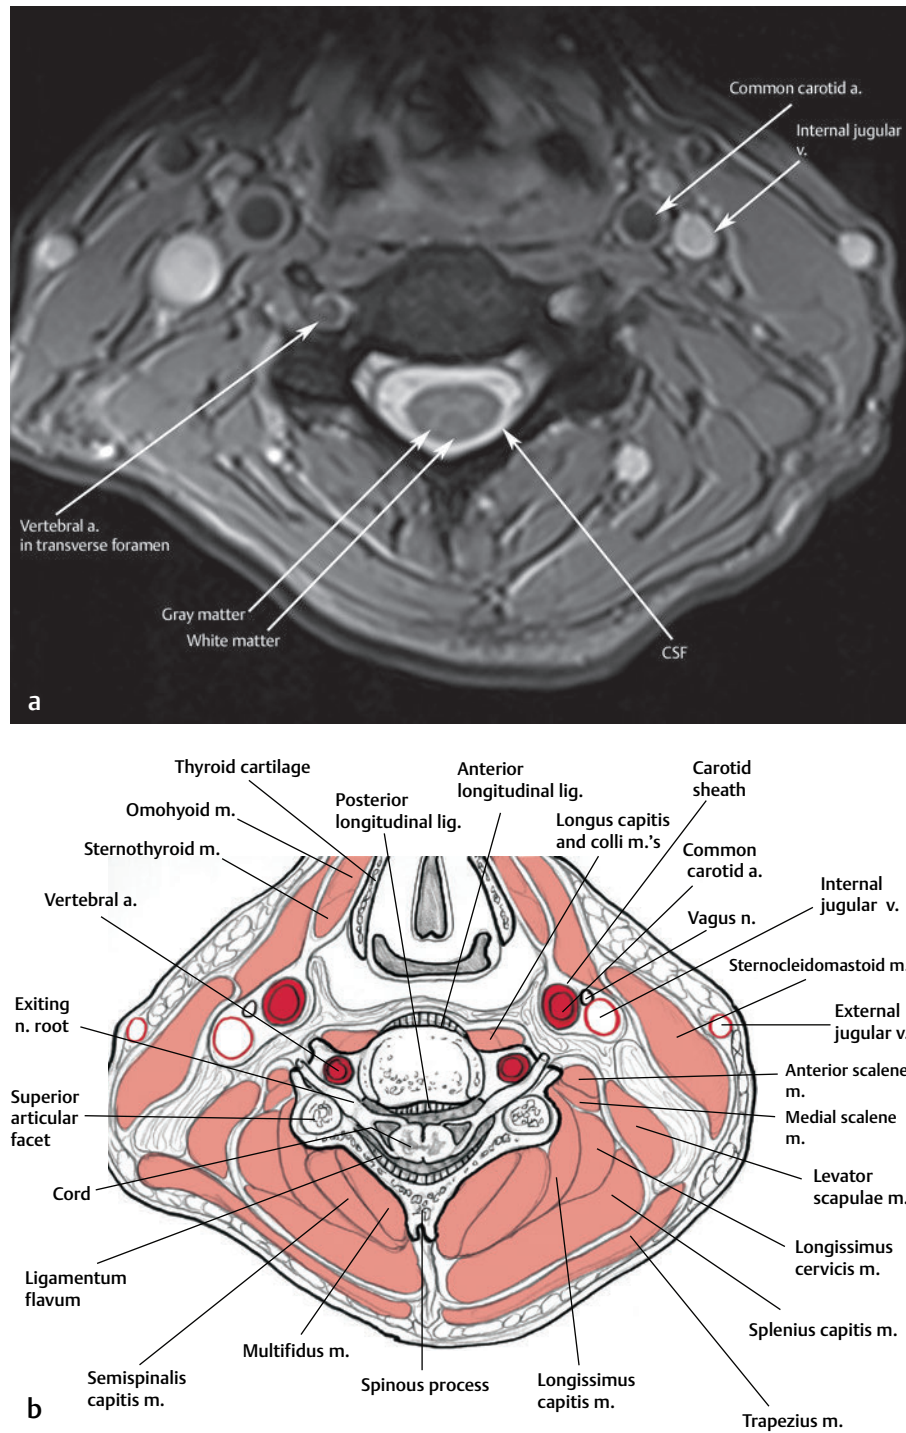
This (a) axial T2-weighted image and (b) artist's sketch clearly define the gray and white matter of the cervical spinal cord, the CSF within the subarachnoid space, and epidural fat. Normal flow voids are seen within the carotid and vertebral arteries.[†]
